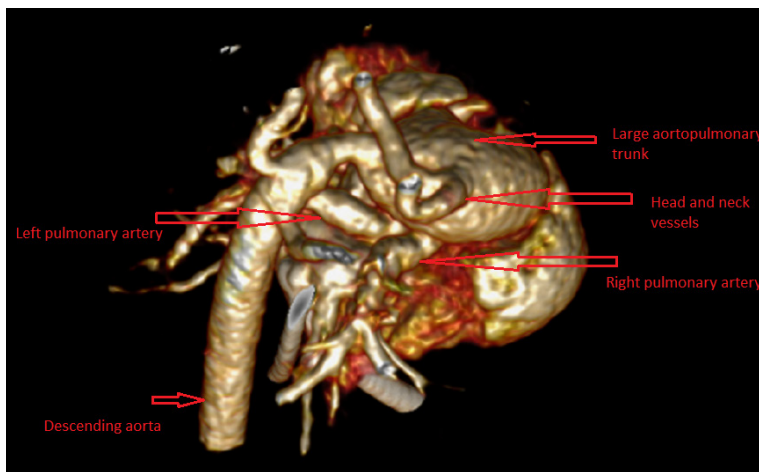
Reconstructed CT image posterior projection showing head and neck vessels and AP window in detail.
